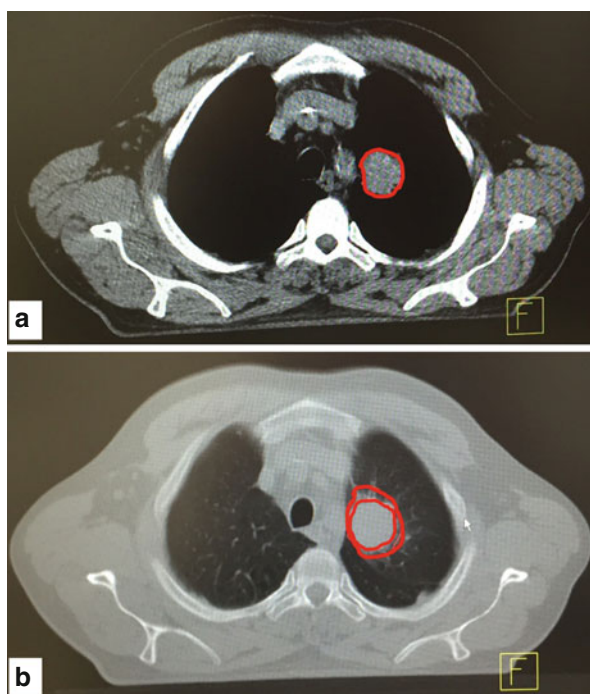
(a) Primary lung tumor on a planning computed tomography (CT) image in “mediastinal windowing.” (b) Same CT image of the primary lung tumor in “lung windowing.” It can clearly be seen that the gross tumor volume (GTV) is enlarged by the addition of the specular extensions
